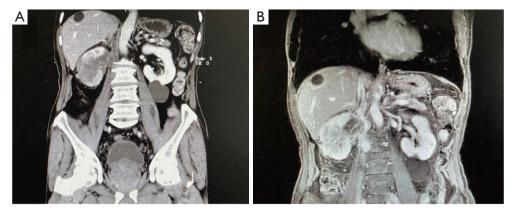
The imaging pictures of Patient 1. (A) The CT image of Patient 1; (B) the MRI image of Patient 1.
